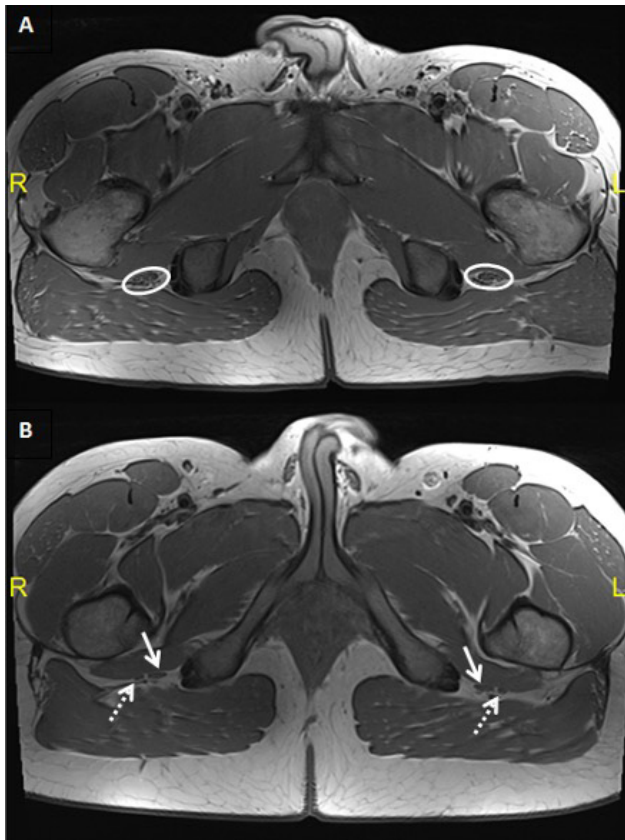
(A) Axial T1-weighted MRI at the ischial tuberosity level revealing a non-split sciatic nerve (white circle); (B) Axial T1-weighted MRI at the ischial tuberosity level revealing a split sciatic nerve with common peroneal (dashed white arrow) and tibial (solid white arrow) components of the nerve.
